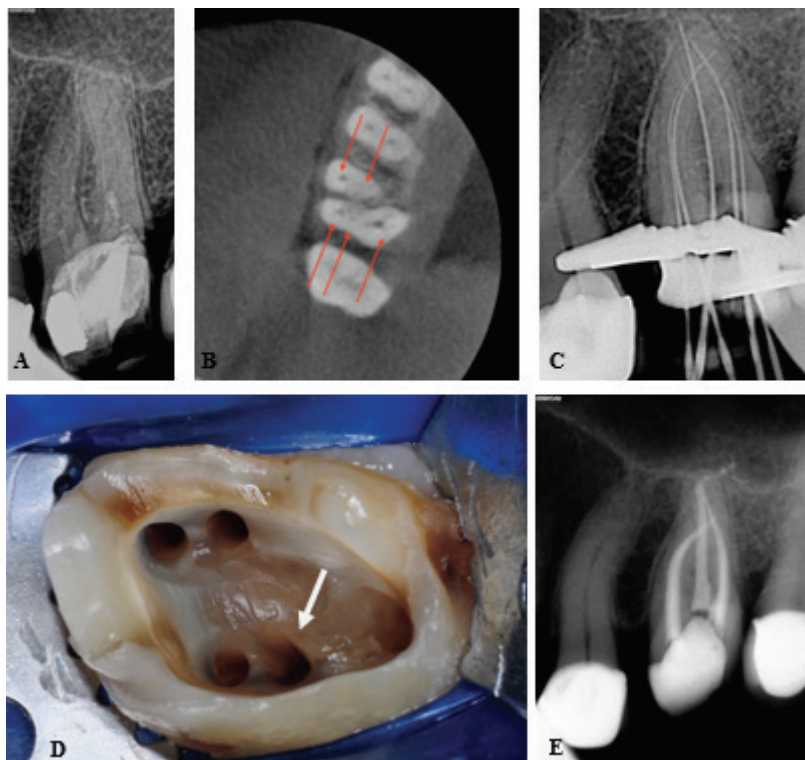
Clinical management of a maxillary first molar with an additional DB canal; (A) Pre-operative periapical radiograph of a left first maxillary molar that presented with an emergency root canal treatment; (B) Axial slice on a CBCT scan revealed the presence of an MB, MB2, P, D and an additional distobuccal (DB) canal system; (C) Periapical radiograph to confirm the working length of the five-root canal systems; (D) High-magnification view of the pulp chamber showing the additional canal in the DB root (white arrow) after canal preparation; (E) Postoperative periapical radiograph after obturation with temporary restoration.
